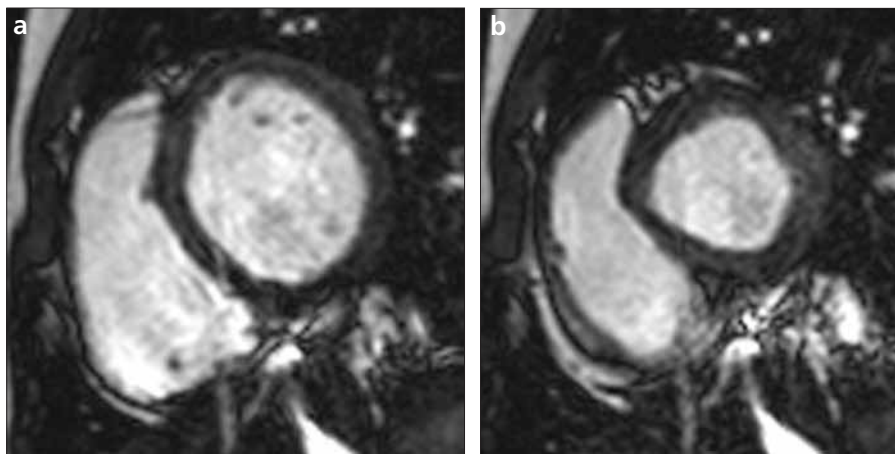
a, b. Short axis multi-segmented cine MR images taken during the end-diastolic phase (a) and the end-systolic phase (b).
